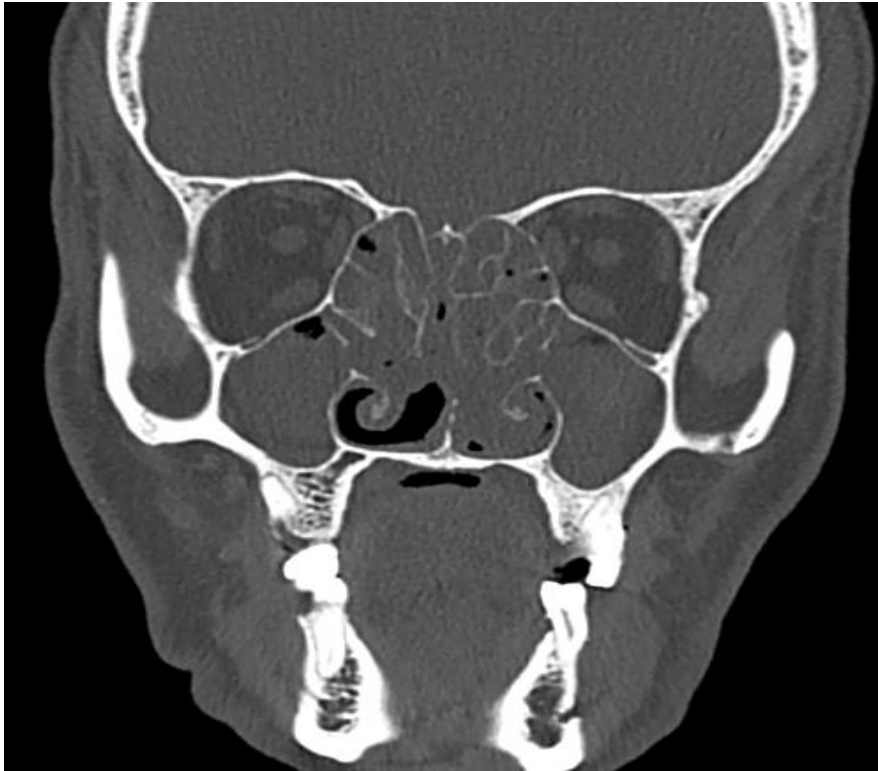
CT PNS coronal section showing bilateral ethmoid and maxillary sinusitis
